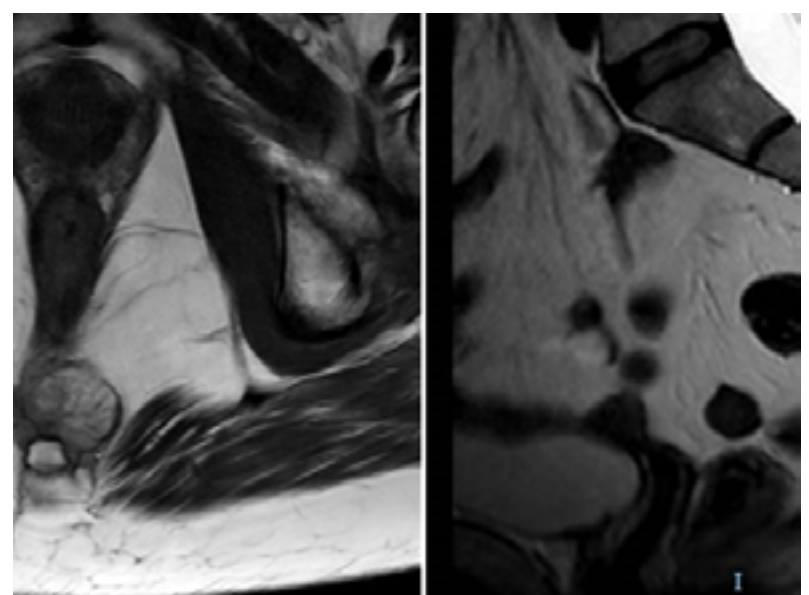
2B: Axial and sagittal views on MRI showing a small tumor of the coccyx, needle Biopsy revealed the diagnosis of chordoma
